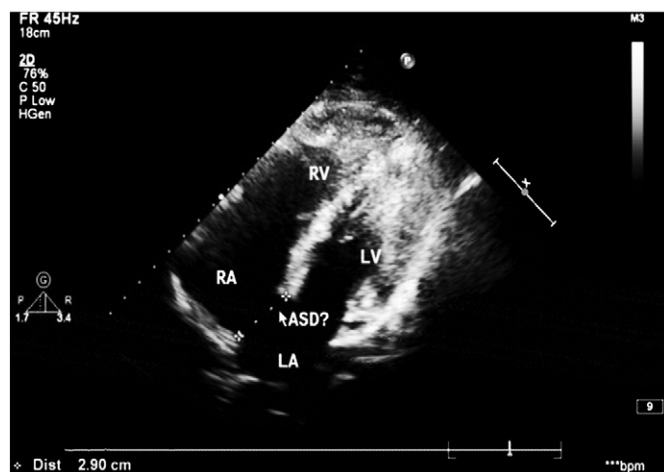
Echocardiogram of the son of the proband. The white arrow points to the site of ASD.
